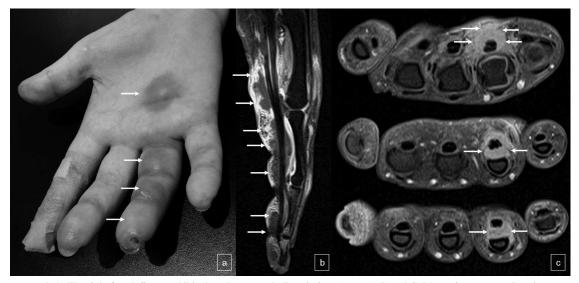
A. The right fourth finger exhibited erythematous bullous lesions (arrows). B and C. Magnetic resonance imaging scans showed extensive fluid collection with peripheral contrast enhancement of the fourth flexor tendon synovial sheath, indicating abscess (arrows).
